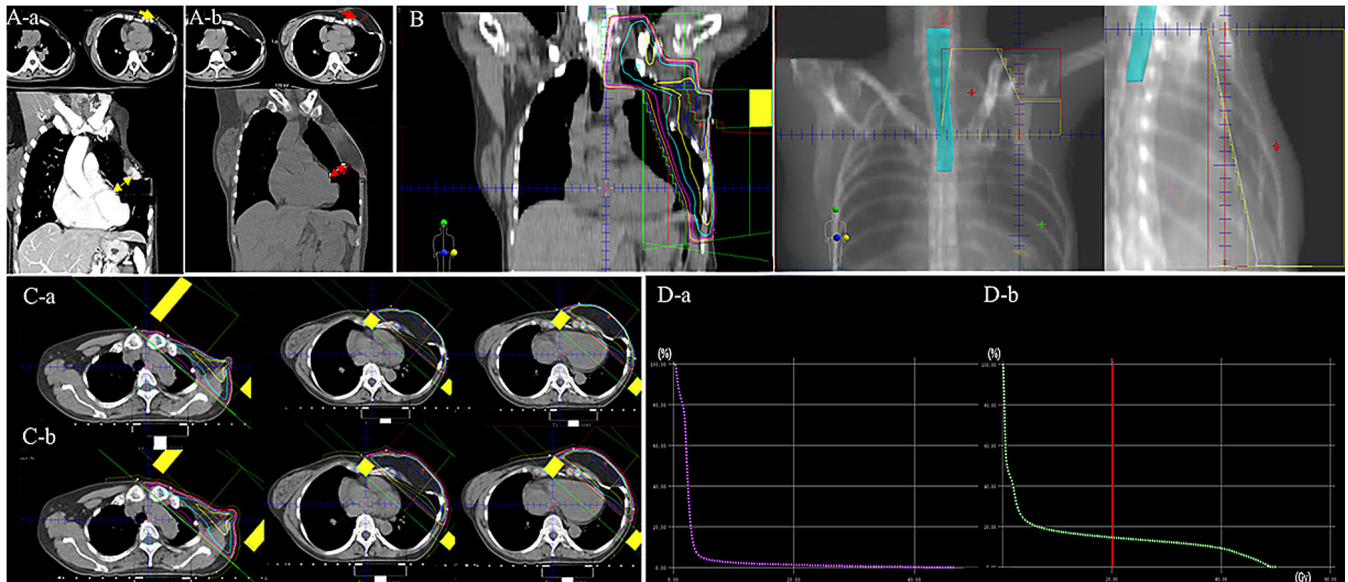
Irradiation method and dosimetric treatment. (A) CT images (axial section, coronal section) following total left mastectomy with axillary dissection and immediate TRAM flap reconstruction. The chest wall is thin, and the distance between the chest wall and heart is similar to that before surgery. Chest wall thickness (A-a) before TRAM flap reconstruction and (A-b) after TRAM flap reconstruction (axial images, yellow arrow: 0.6 cm, red arrow: 2.5 cm, yellow double arrowhead: 2.3 cm, red double arrowhead: 2.6 cm). (B) Radiotherapy field. RT was administered to the chest wall at 50 Gy in 25 fractions (six portals) using bolus and field-in-field tangential techniques and to the supraclavicular and infraclavicular lymph node areas at 50 Gy in 25 fractions (one portal) with 4-MV X-rays. Then, these two irradiation fields were connected using the half-field technique. A dose distribution of 50 Gy in 25 fractions is the prescribed total dose (coronal section). The central lung distance on the central axis plane is within 3.0 cm, thus meeting our institutional standards. (C) Final treatment plan including the tilting technique. A dose distribution of 50 Gy in 25 fractions is the prescribed total dose with or without the 5-mm bolus (axial section). The X-ray beam was arranged such that the 95% isodose line (yellow line) covered the remaining chest wall at the level of the sixth and seventh ribs and extended perpendicularly from the skin surface. A 5-mm bolus was used to optimize the skin dose while considering the effect of build-up: (C-a) Upper section: Without the bolus, 21 Gy in 25 fractions; (C-b) lower section: With the bolus, 25 Gy in 25 fractions. (D) The DVH shows the doses to the heart: (D-a) Mean heart dose, 2.74 Gy to the heart; (D-b) V20 dose of 14.6% to the lungs indicated by the red line. CT, computed tomography; TRAM, transverse rectus abdominis myocutaneous; RT, Radiation therapy; DVH, dose-volume histogram.
